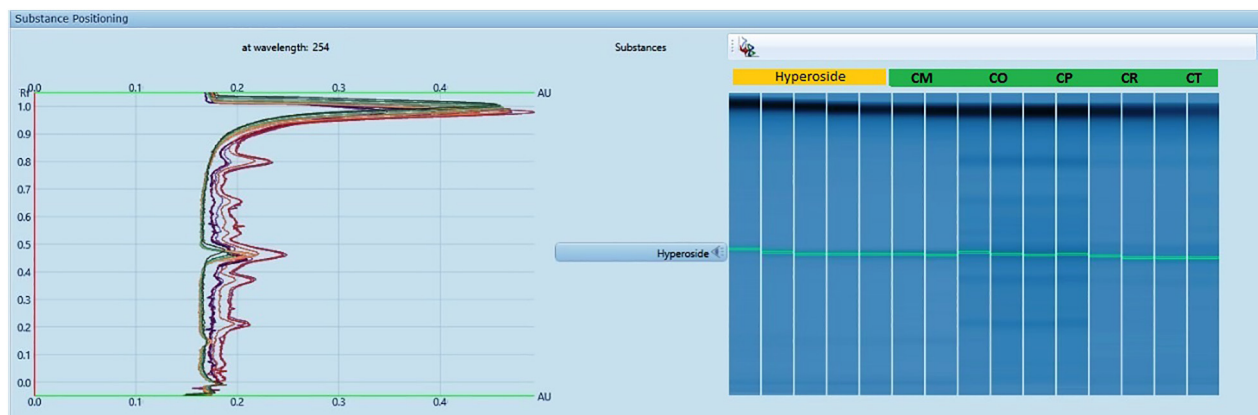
Densitometric chromatogram of hyperoside and *Crataegus* extracts (CM: *C. monogyna*/CO: *C. orientalis*/CP: *C. pontica*/CR: *C. rhipidophylla*/CT: *C. turcicus*).
